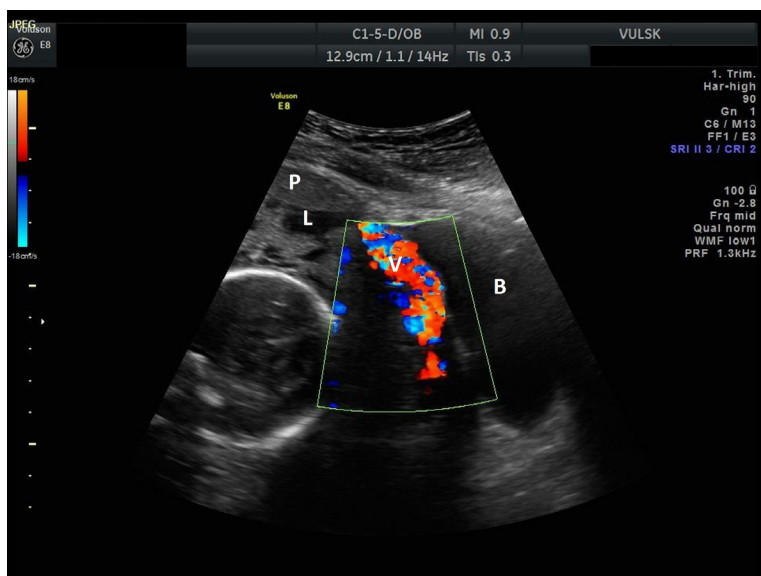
An ultrasound image in Doppler mode. Abdominal probe. Lacunar spaces (L) of various size and irregular are present in the placenta (P). The posterior wall of the bladder (B) is convex. An active heterogeneous blood flow (V) is observed near the bladder and in the placenta
